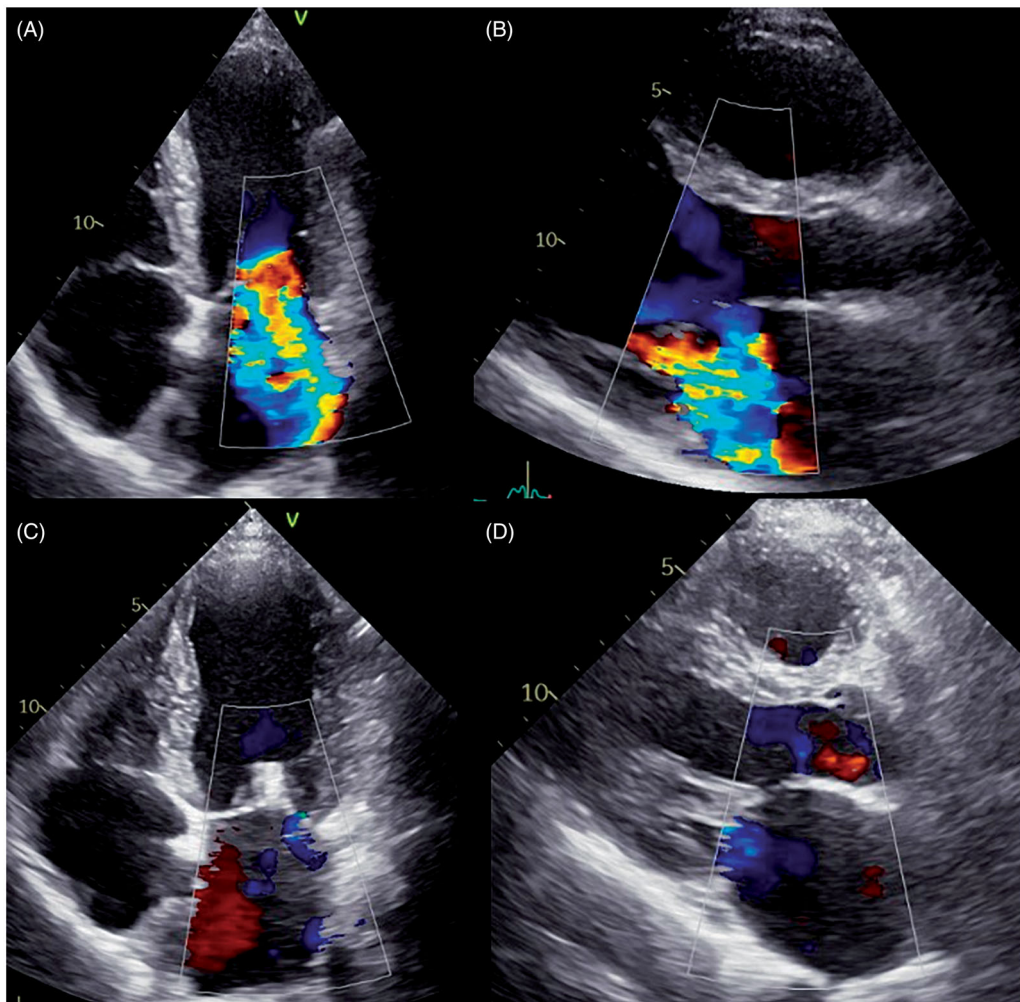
Apical four-chamber view (A) and parasternal long-axis view (B) showing severe mitral regurgitation. A marked improvement is observed after transcatheter edge-to-edge mitral valve repair (C,D).
